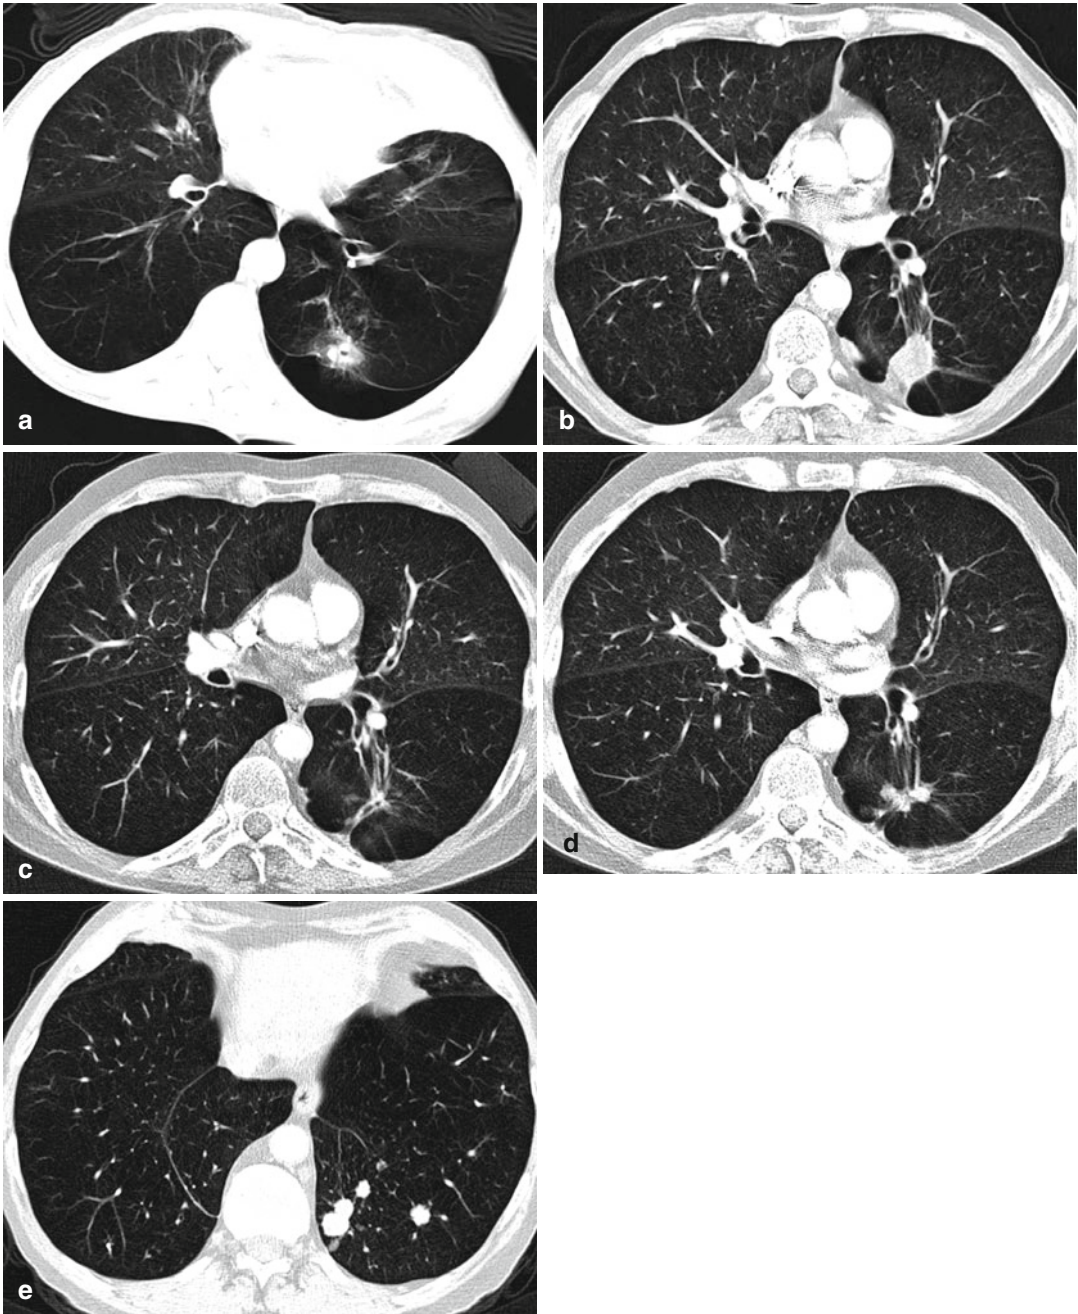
(a–e) Small intra-procedural pneumothorax occurred during percutaneous RF ablation of an early-stage NSCLC of the left lower lobe (a). Note the underlying lung emphysema. On the follow-up CT scan after 3 months, the treated tumor increased in size, exhibiting pleural contact in the region of the needle entry (b). The CT scan 6 months
